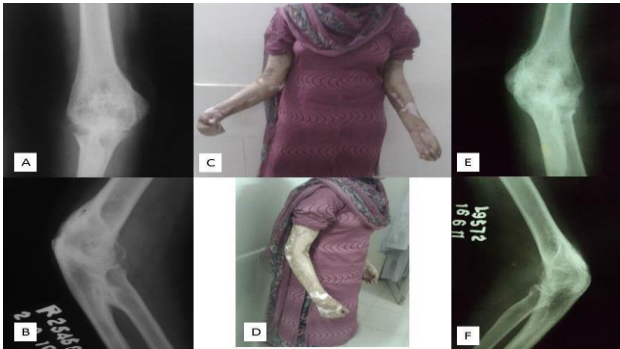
(A) Pre-operative radiograph of right elbow, anteroposterior view; (B) Pre-operative radiograph of right elbow, lateral view; (C) Pre-operative clinical picture, anteroposterior view; (D) Pre-operative clinical picture, lateral view; (E) Pre-operative radiograph of left elbow, anteroposterior view; (F) pre-operative radiograph of left elbow, lateral view.
